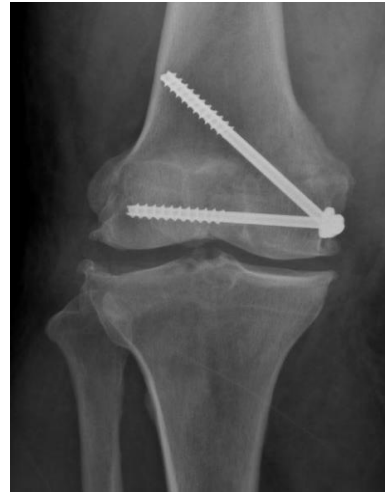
Post-operative anteroposterior (AP) x-ray of the patient's knee showing anatomically-reduced fracture fixed with two 7.3 mm cannulated screws
